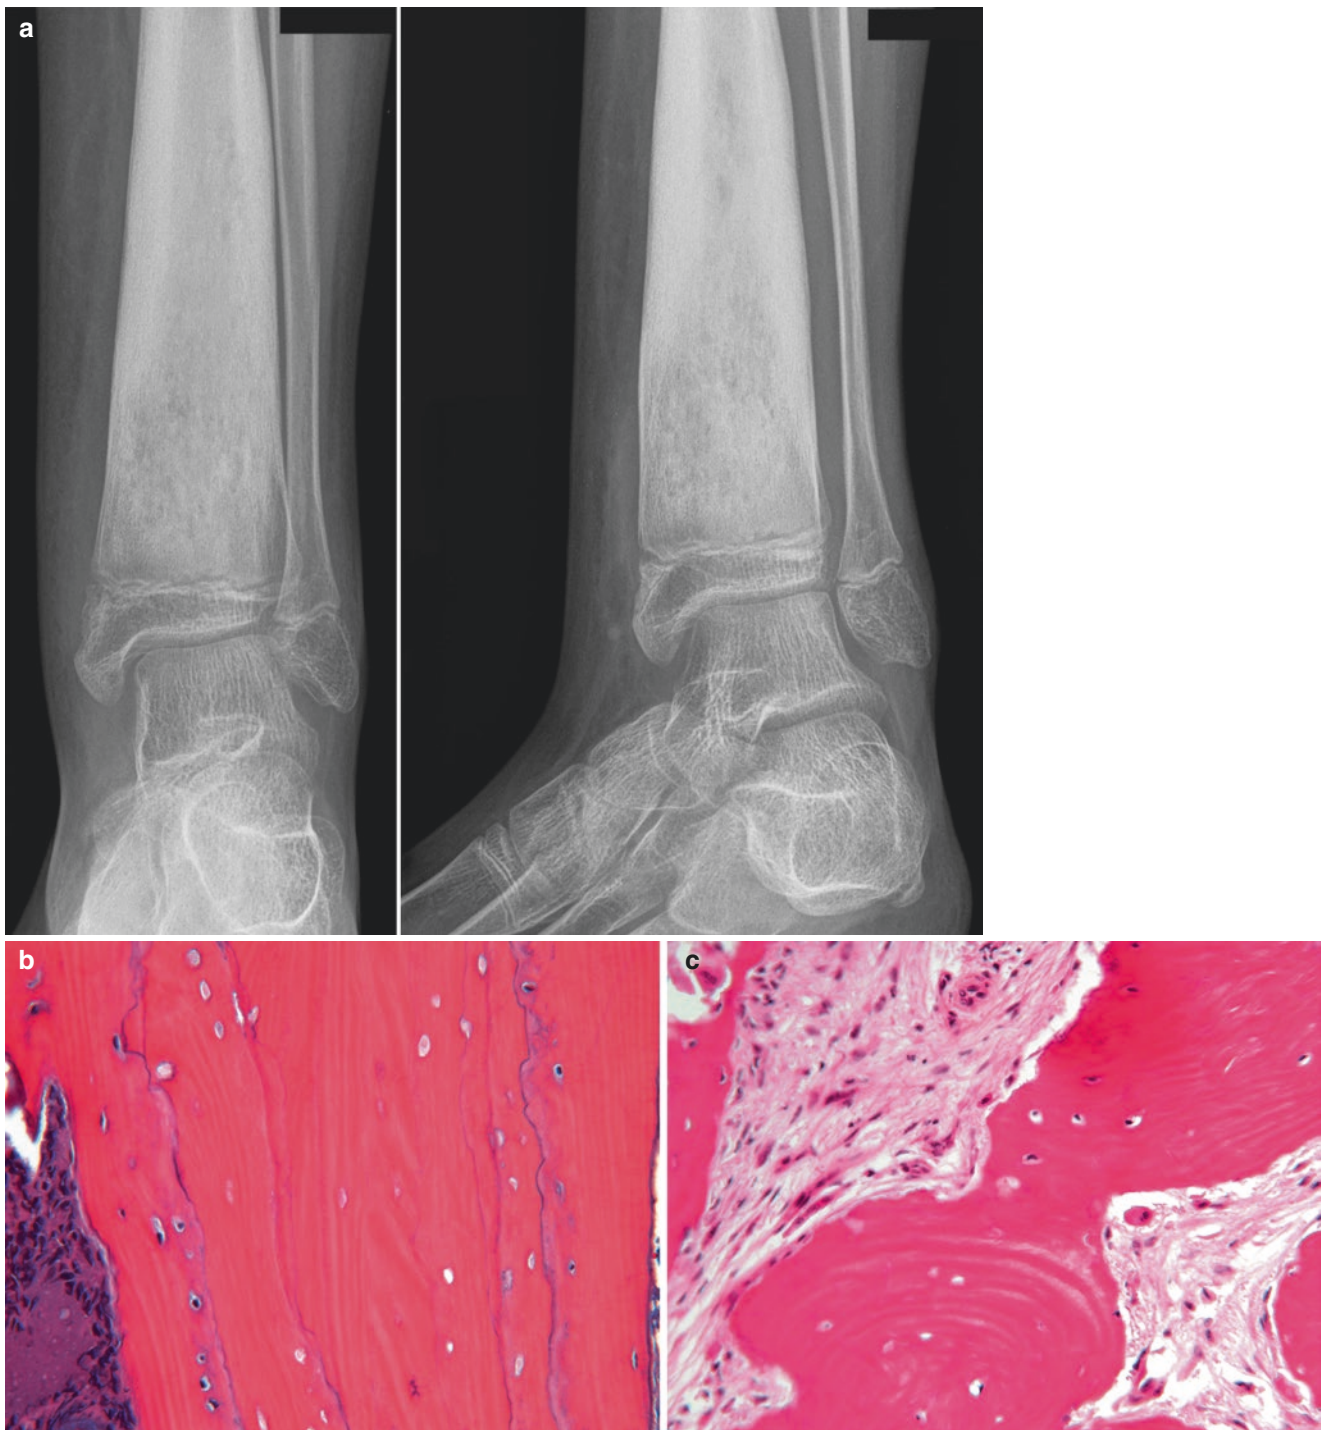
(a) This 12-year-old girl had been experiencing lower leg pain for months with occasional episodes of low-grade fever. Her distal leg was tender and had soft-tissue swelling. The radiographs demonstrated diffuse distal sclerosis of the tibia, containing a few irregular radiolucencies. There was a modeling deformity of the distal tibia, with a loss of normal taper and increased anteroposterior diameter and organized periosteal new bone formation. (b) A biopsy including tibial cortex demonstrated waves of thickening and remodeling of the compact bone marked by long cement lines separating layers of the lamellar
